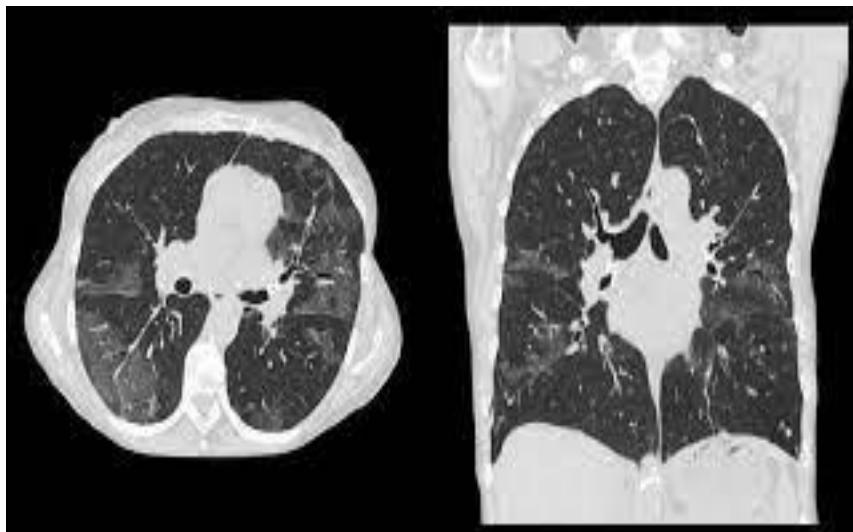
MRI image of the lungs.
